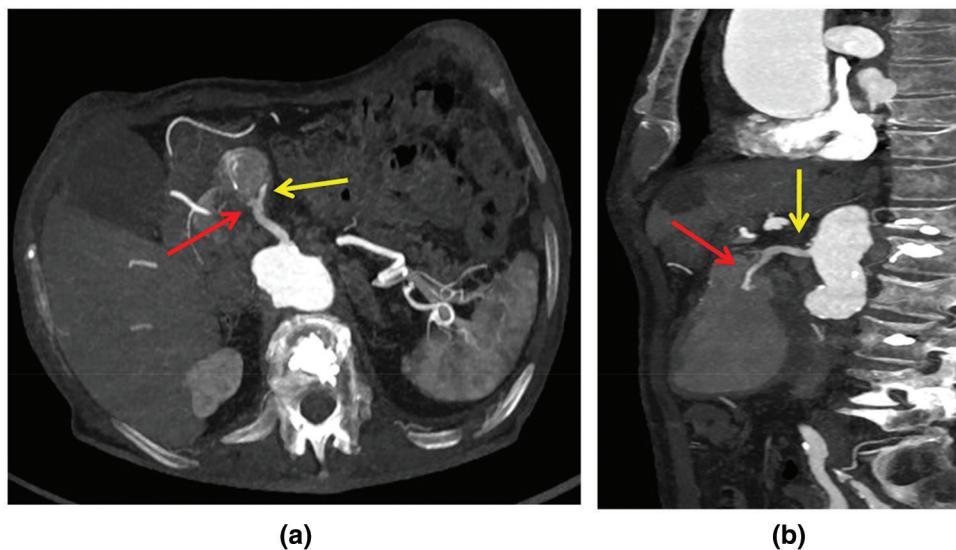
Preliminary CT scan. Maximum intensity projection (MIP) reconstructions showing the oblique axial (a) and sagittal (b) planes, the origin of the middle colic artery (red arrows) and in-flow tract of the giant pseudoaneurysm from the superior mesenteric artery (yellow arrows).
